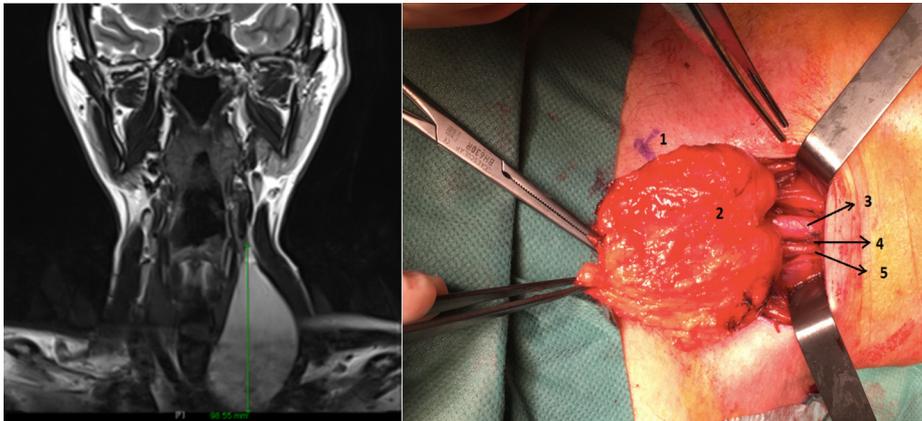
Left: MRI preoperatively. Right: per-operative images: 1. sternal notch; 2. lipoma mass; 3. common carotid; 4. vagus nerve; 5. internal jugular vein.
